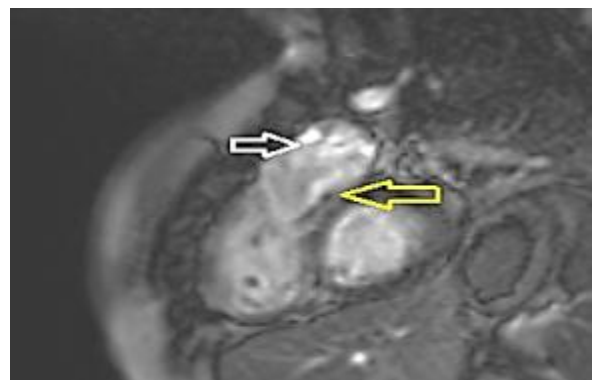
MRI RVOT view LGE sequence shows RVOT enhancement (white arrow) and RV upper insertion point enhancement (yellow arrow).
